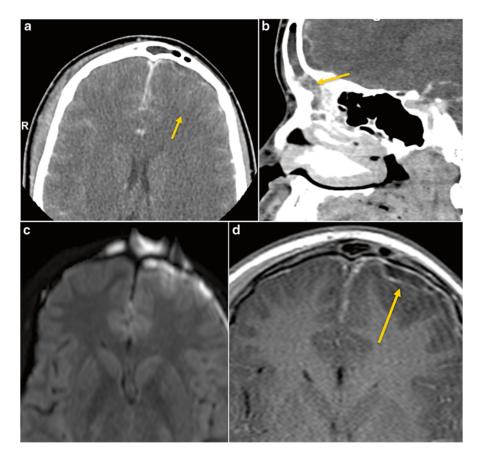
Subdural empyema. (a) Axial and (b) sagittal post contrast CT images show a peripherally enhancing subdural empyema in the left anterior frontal convexity secondary to complicated acute sinusitis from the frontal sinus. (c) Axial MRI diffusion (DWI) sequence and (d) post-axial T1 showing left frontal subdural empyema and anterior frontal lobe cerebritis secondary to frontal sinus abscess with restricted diffusion. Restricted diffusion is also noted in the abscess. There is associated dural thickening and enhancement in the contralateral frontal convexity and interhemispheric fissure
